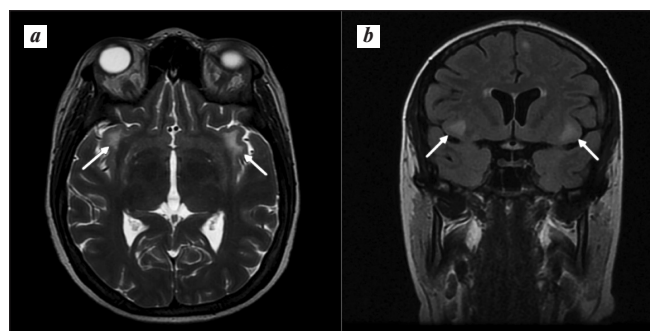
The result of an MRI scan of the brain of patient O. in the axial section in T2 mode (a), in the sagittal section in T1 mode (b), and in the coronal projection in FLAIR mode (c).
